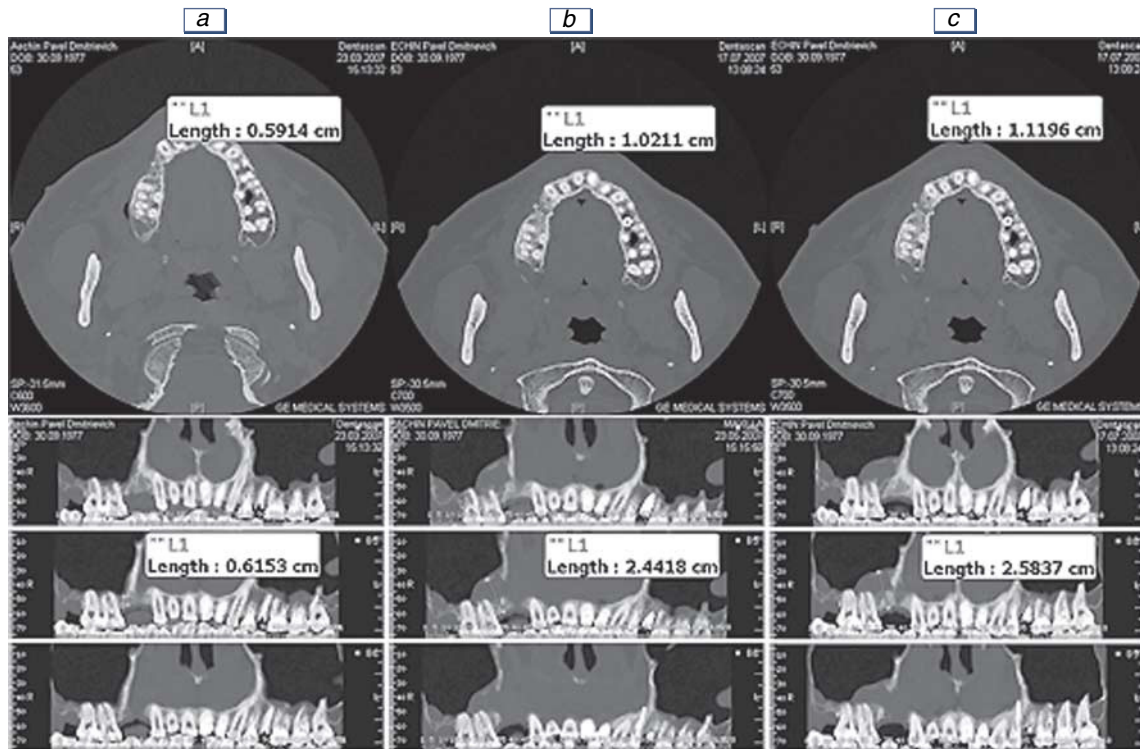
Patient E., 29-year-old men. CT of facial bone skeleton. a) before treatment; b) 1 month after transplantation of tissue-engineering construct; c) 3 months after transplantation.
